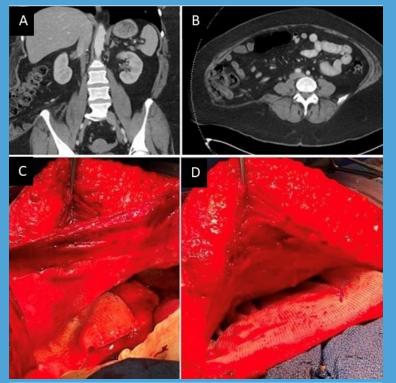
(A) Computed topography (CT) scan with coronal view of large lumbar hernia. (B) CT scan with axial view of large lumbar hernia. (C) Intra-operative photograph of biologic mesh placement. (D) Intra-operative photograph of retrorectus mesh placement.
